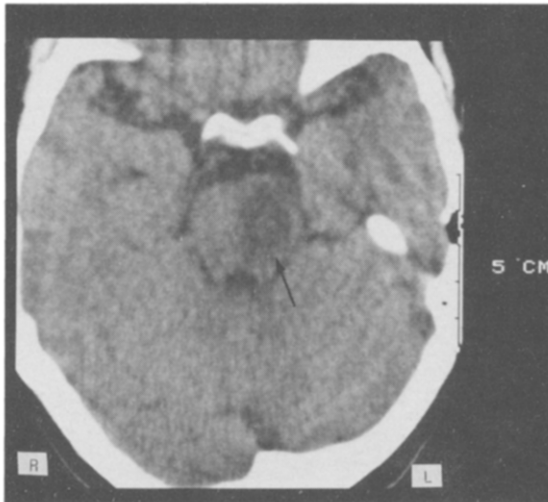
CT scan showing a hypodense lesion (←) in the pons consistent with recent infarction.
